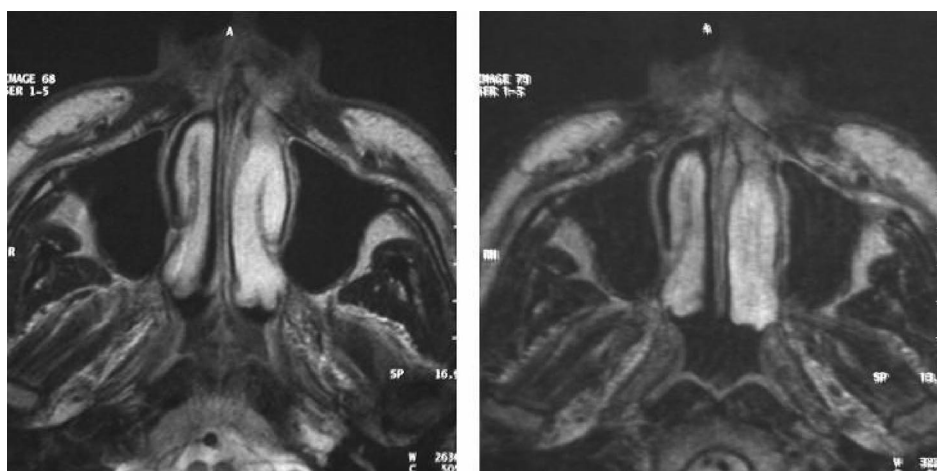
Magnetic resonance image of preoperative and postoperative axial sections.
